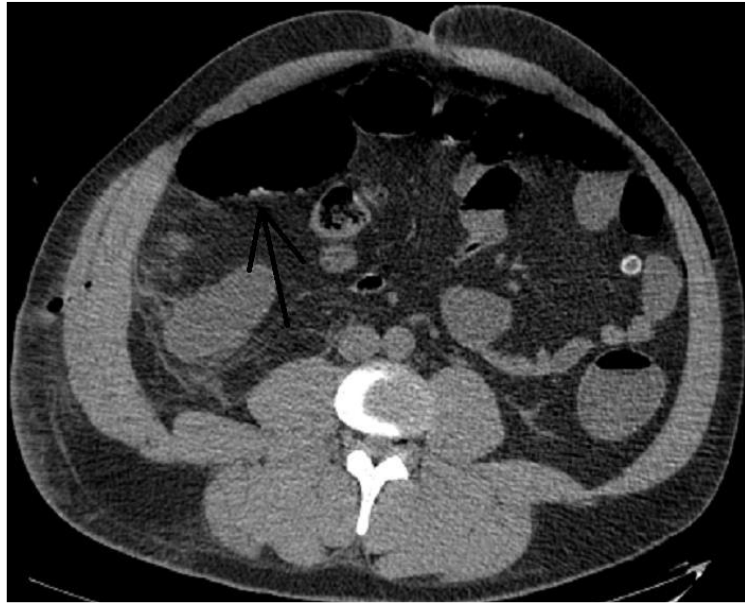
CT scan of the abdominal organs, axial projection. Free gas in the abdominal cavity and retroperitoneum (arrows).
